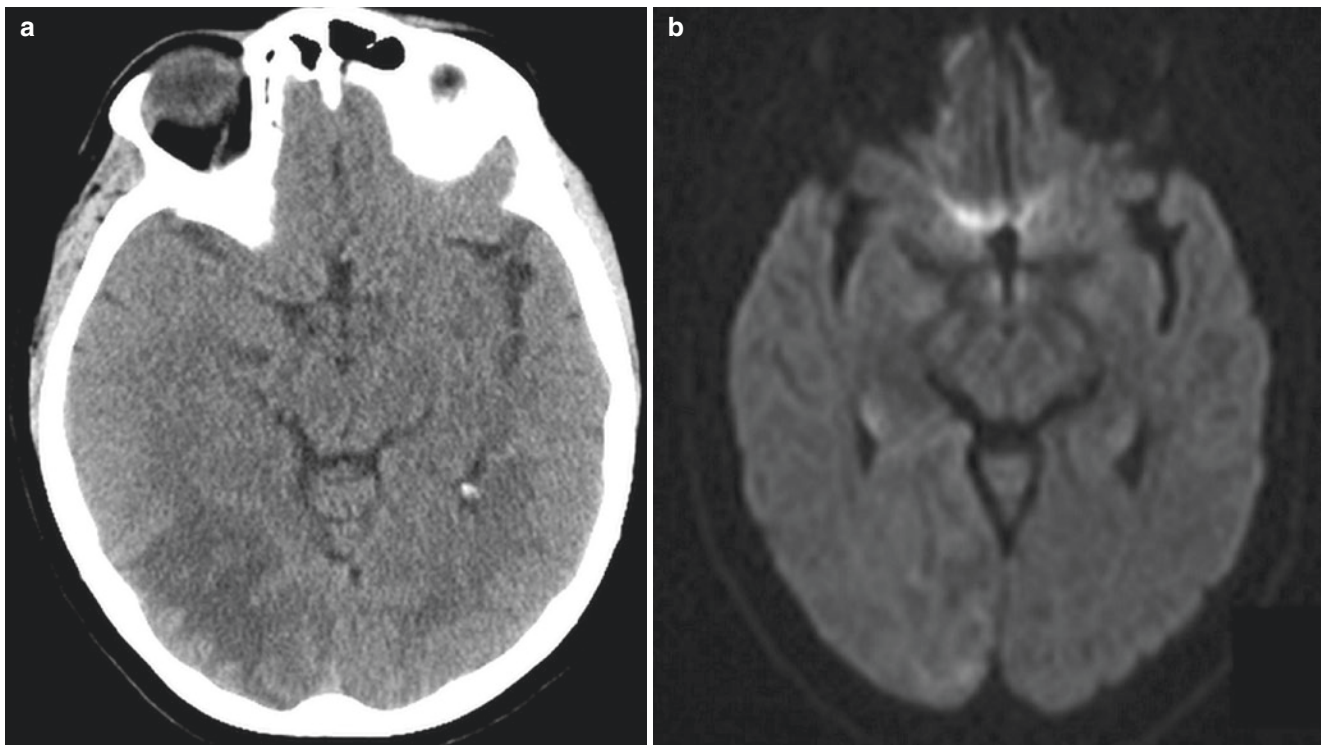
Subacute infarction mimicking tumor. Patient presents with visual disturbance. (a), NCCT shows vasogenic edema in the right occipital lobe. MRI brain demonstrates minimally increased diffusion signal (b), FLAIR hyperintensity (c), and gyriform enhancement (d) in the right occipital lobe. CT perfusion shows hypoperfusion in this
